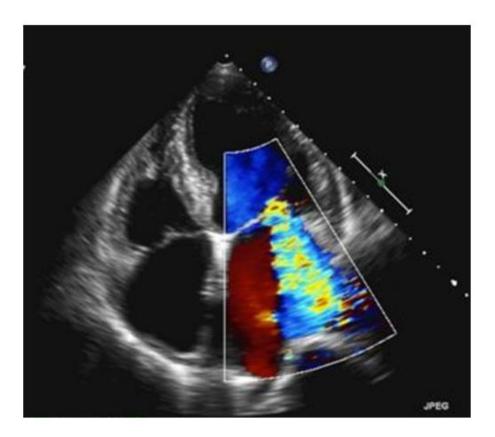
Echocardiogram, four chamber apical view with colour doppler showing moderate mitral regurgitation jet.
